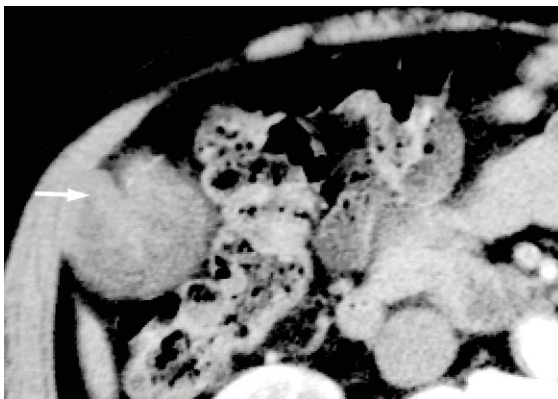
Non-contrast enhanced computed tomography showed a cauliflower-like soft tissue mass with some calcified spots in the fundus of the gallbladder with gallbladder wall retraction (arrow).
